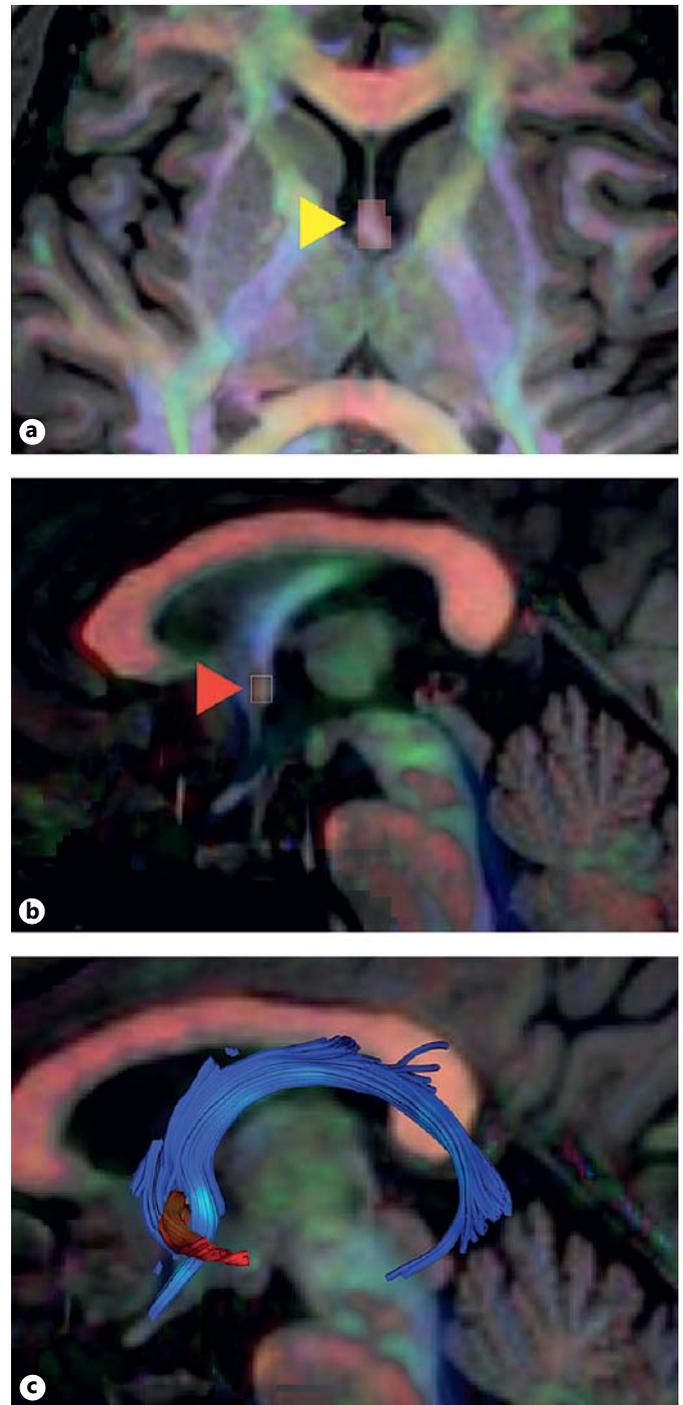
DTI model reconstruction using deterministic tractography. a Axial slice of a sample brain with the T1-weighted anatomical scan superimposed onto the DTI image of the same subject. The DTI image is shown in color-by-orientation (red: left-right; green: anterior-posterior; blue: superior-inferior). The yellow arrowhead denotes the seeding ROI. b Midsagittal slice; the red arrowhead denotes the ROI for AC seeding. c Sagittal representative fornix tractography reconstruction overlaid onto the combined DTI tensor/anatomical image.
